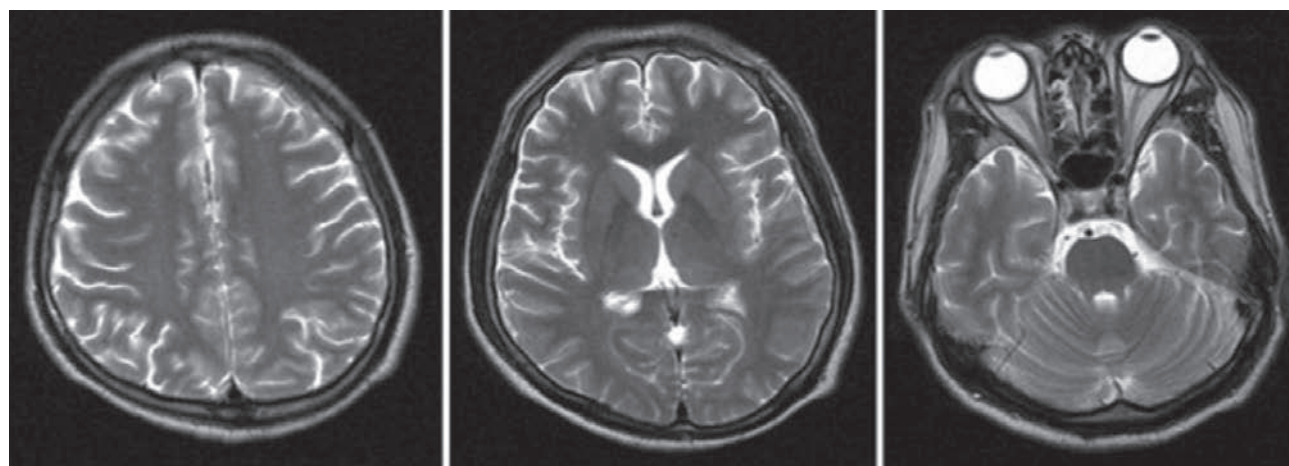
T₂-weighted MRI showing mild diffuse cerebral atrophy.
